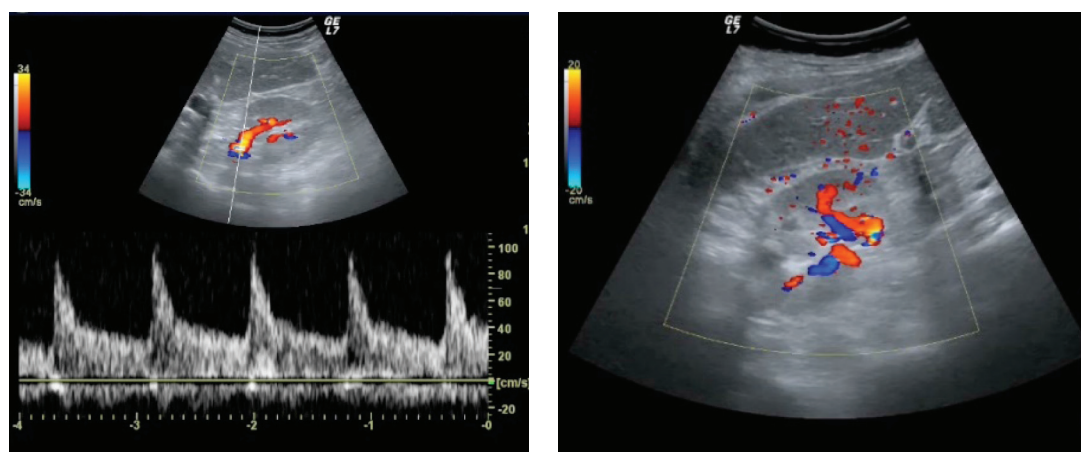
Doppler ultrasonography confirming successful treatment
